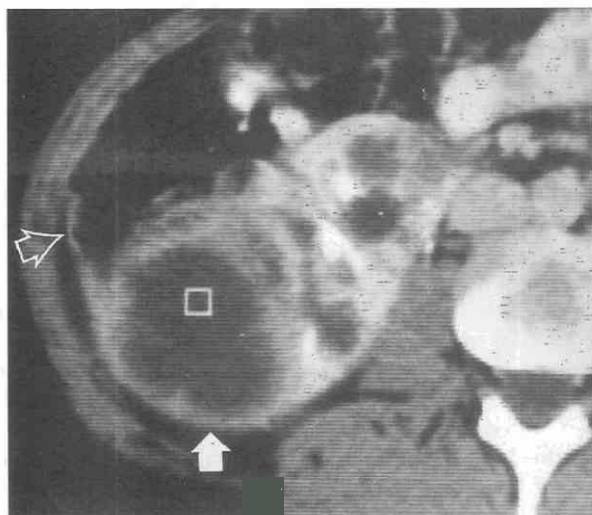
Acute pyelonephritis complicated by cyst infection in autosomal dominant polycystic kidney disease. A lower pole cyst (solid arrow) is larger than adjacent cysts and shows an irregular, thickened wall and adjacent renal fascial thickening (open arrow). The patient demonstrated a response to antibiotic therapy, and a follow-up sonogram showed absence of the large cyst, suggesting rupture into the collecting system. (From Levine E, Grantham JJ: Calcified renal stones and cyst calcifications in autosomal dominant polycystic kidney disease: Clinical and CT study in 85 patients. *AJR Am J Roentgenol* 159:77-81, 1992.)
